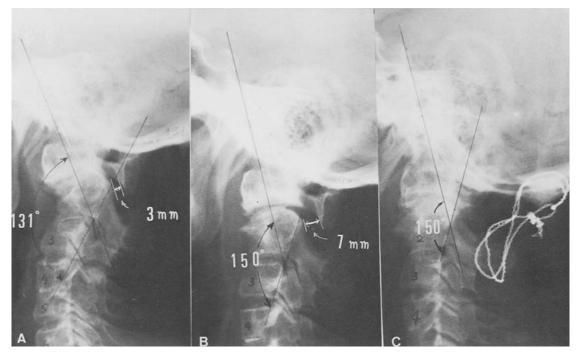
Partial reducible atlanto-axial dislocation. Lateral x-rays in full-extension of the neck before (A) and after intensive skeletal traction with 20 kg in extreme hyperextension of the neck (B). Note, widening of effective A–P diameter at C1–2 of 3 mm in "A", increased up to 7 mm in "B". Acute clivo-axial angle of 131° (normal range; 158° – 177°) rendered a less acute angle of 150° with slight reduction of anterior dislocation of C1 on C2. Postoperative x-ray (C) shows occipito-C2 fixation with twisted wires and acrylic done with reduced clivo-axial angle of 150°. Posterior arch of C1 is not seen (Case 41. 41-year-old female).
